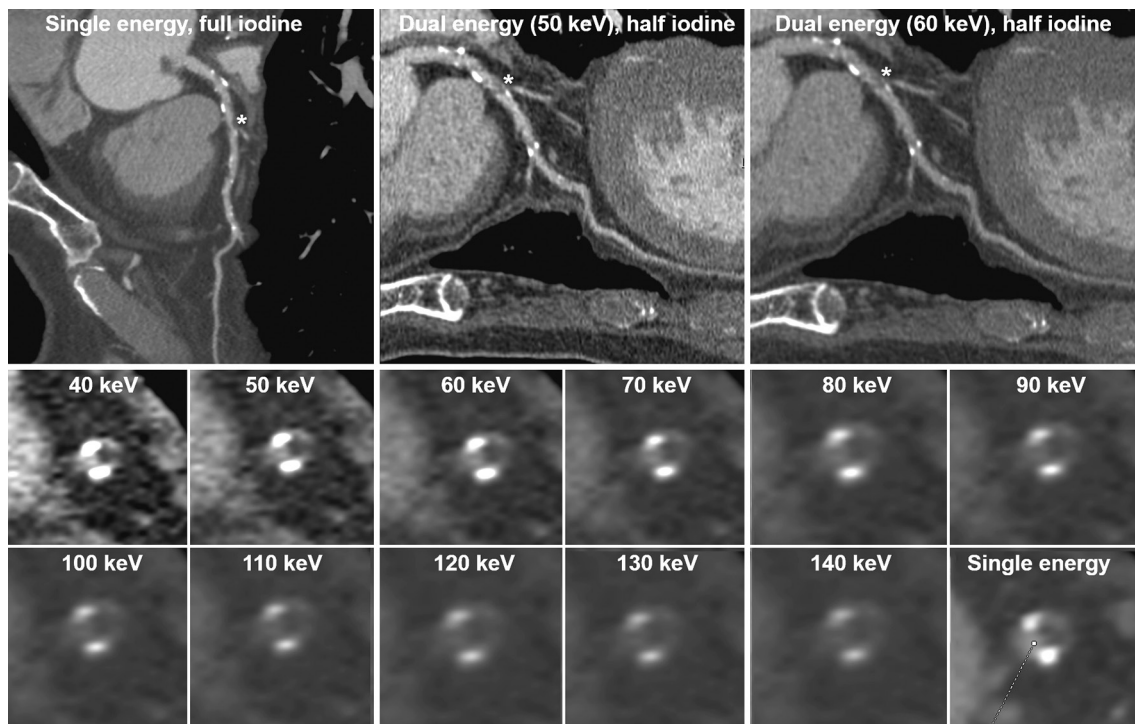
Curved multiplanar reconstruction of a left anterior descending artery (LAD) acquired using single energy CT at full iodine load, and dual energy CT at half iodine load. A significant mixed lesion (*) is observed at the the proximal LAD, similarly depicted with both strategies. Orthogonal views at increasing energy levels and using single energy CT are also depicted.
